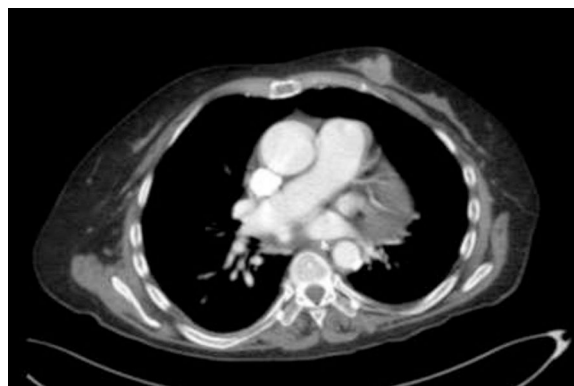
Full-body CT scan. Nodular lesion with poorly defined edges in the left thoracic wall, corresponding to breast cancer.
